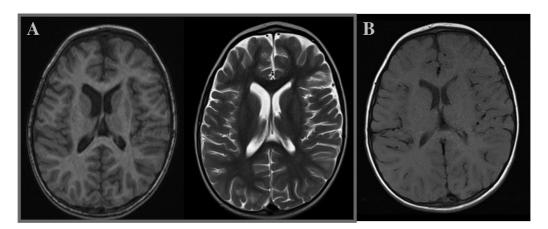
(A-B) Brain magnetic resonance imaging of the patient 1. Axial T1W and T2W images show mild cerebral atrophy on admission.
